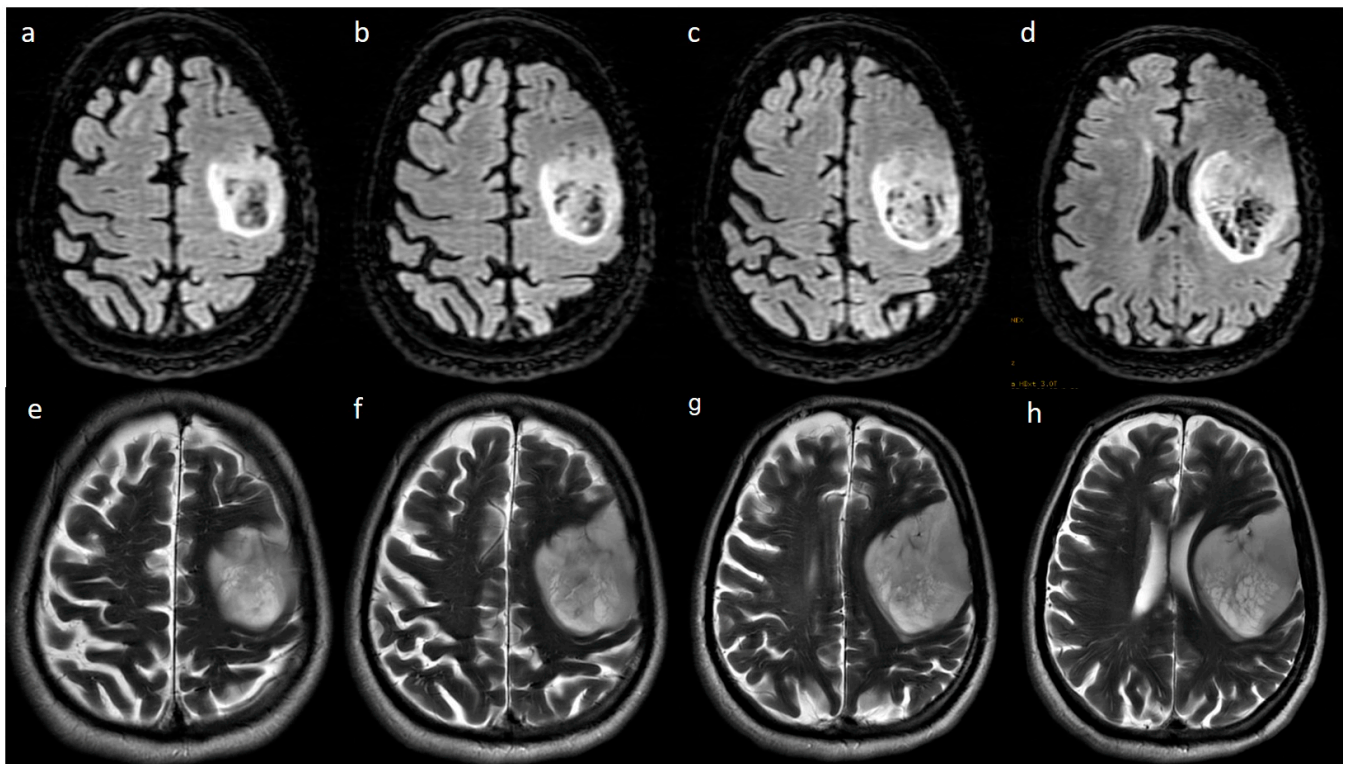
Axial FLAIR (a–d) and T2w (e–h) images reveal a T2-FLAIR mismatch sign in the form of hypointensity within the central part with the hyperintense rim on FLAIR, while both are hyperintense on T2.
